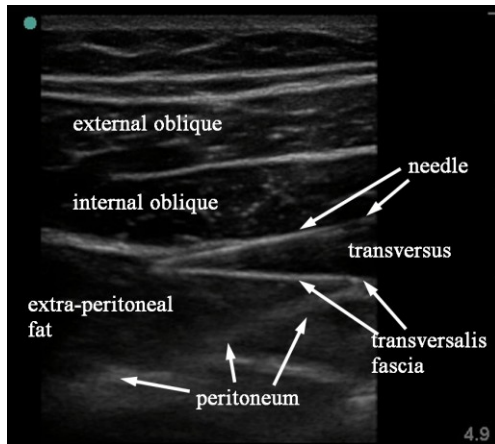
sonogram of the same patient as above showing needle in position for TFP block.
